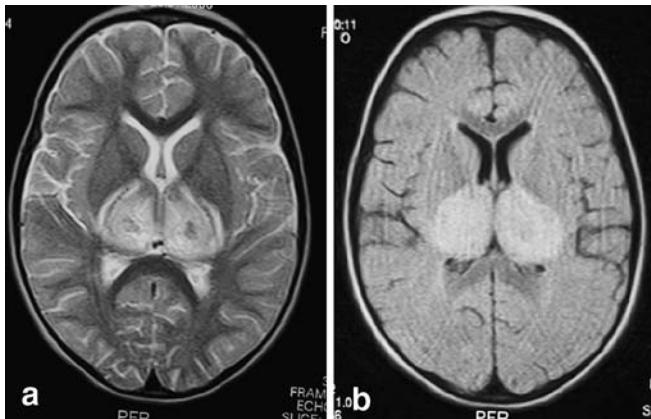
At 5-day follow-up, axial T₂-weighted (MRI) image shows mild reduction of hyperintensities in thalamus with central hypointensity (a). Fluid-attenuated inversion-recovery image confirms the bithalamic hyperintensities (b)
